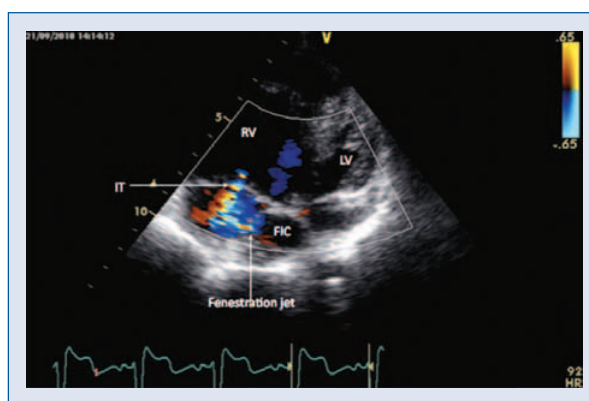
Unbalanced common atrioventricular canal after the Fontan operation — a four-chamber view with color Doppler imaging; RV — right ventricle; LV — rudimentary left ventricle; FIC — fenestrated intraatrial conduit; IT — tricuspid insufficiency.
